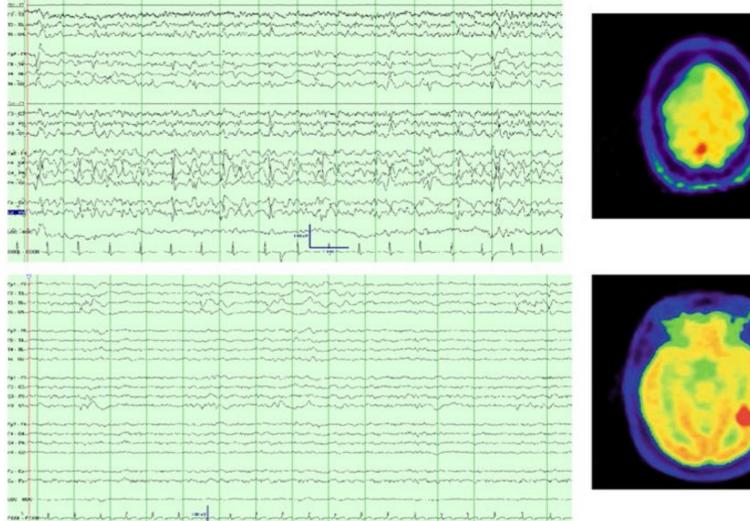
EEG on day 18 showed considerable irritability, with fluctuating degrees of sharp wave activity, but nonetheless was improved from that of day 3. FDG-positron emission tomography on day 17 demonstrated that left mesiotemporal lobe, although showing glucose metabolism comparable to that of the right side and thus reduced as compared with the previous scan, still displayed more metabolism than the left laterotemporal lobe and therefore remained relatively hypermetabolic.
